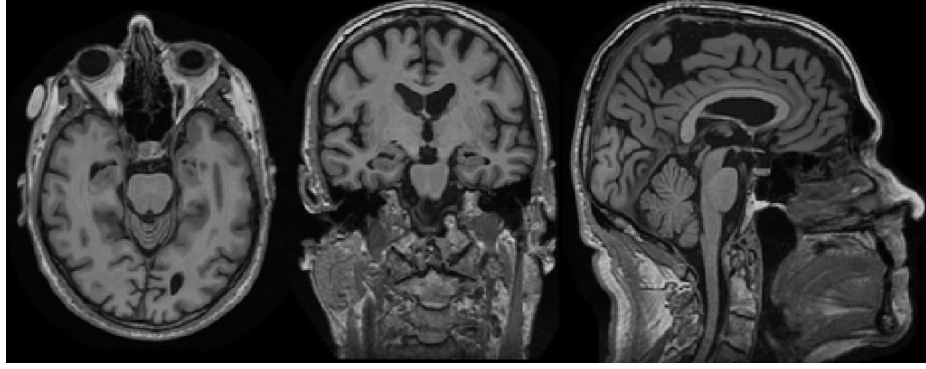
An example of healthy control. From left to right: axial slice, coronal slice, sagittal slice of the T1 weighted MRI scan.
